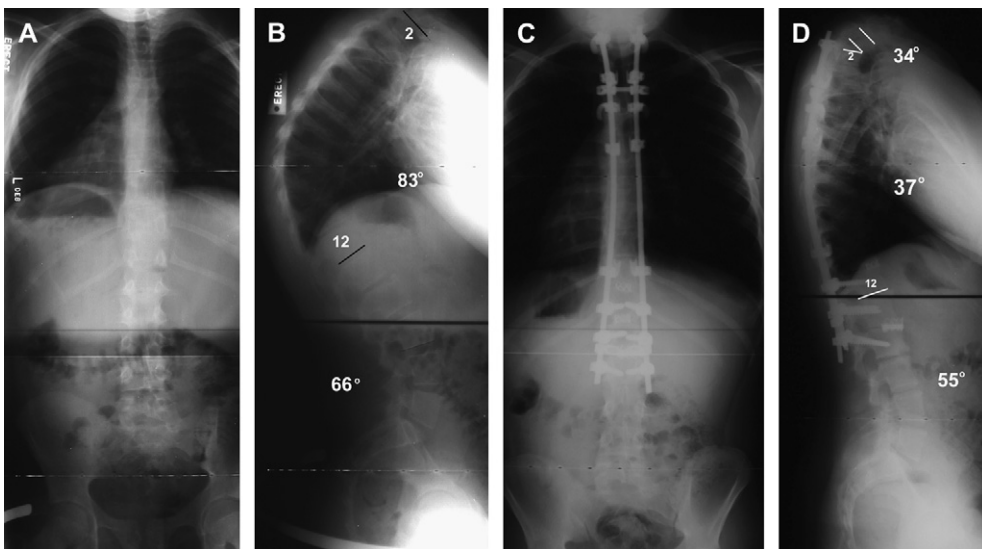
(A–D) Pre- and postoperative radiographs demonstrate proximal junctional kyphosis related to excessive correction of kyphosis (>50%).
